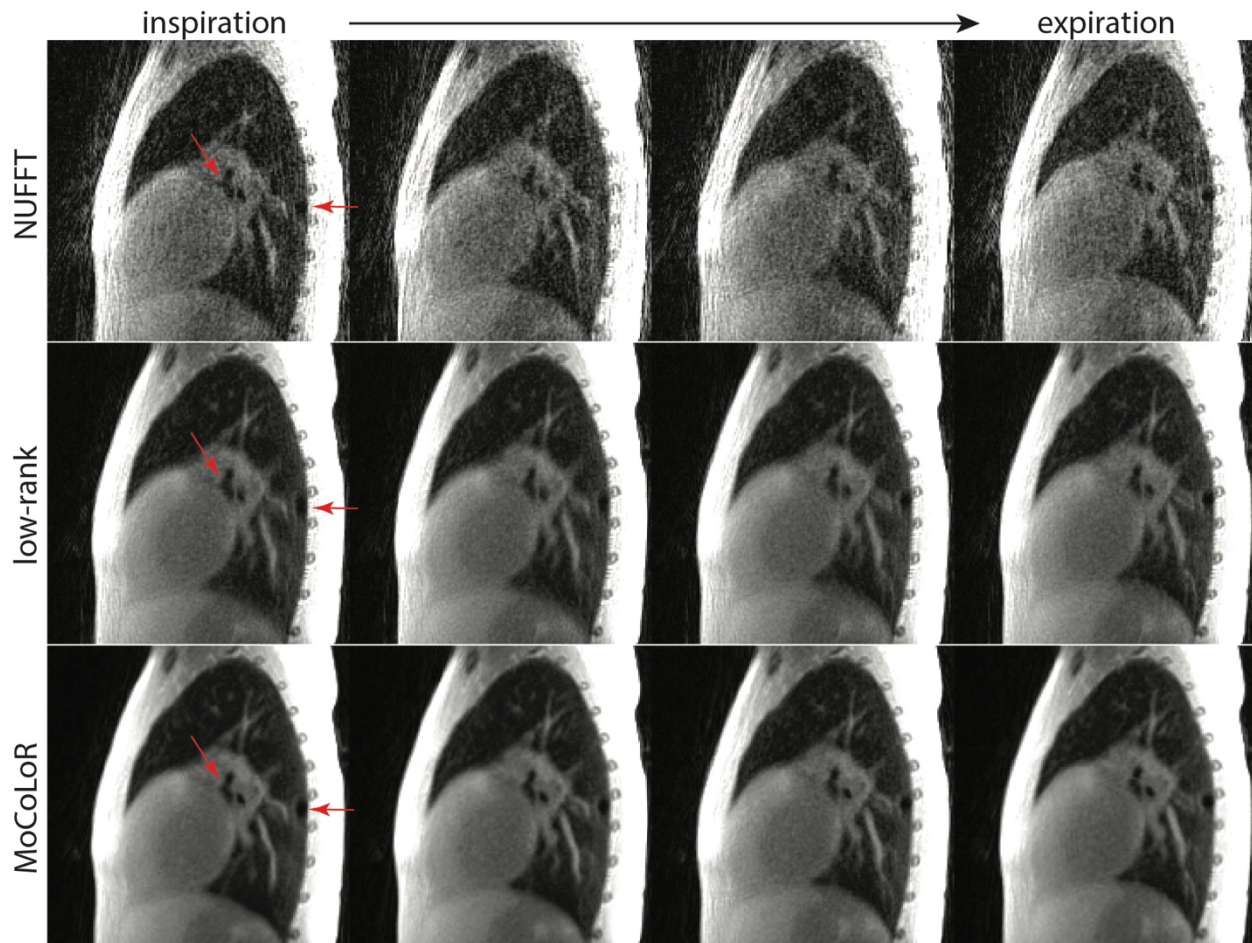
Pediatric patient lung MRI study. A pediatric patient was scanned free-breathing with the 3D UTE sequence. Motion resolved images reconstructed by the three different methods from expiration state to expiration state are shown. A small lung cyst, and main airways are pointed to by red arrows.
